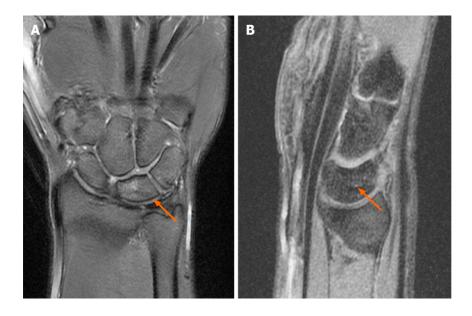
Magnetic resonance imaging follow-up 18 mo postoperatively. A: Coronal section; B: Sagittal section. These findings showed almost completely resorption of bone edema of the lunate (arrow) and did not progress into osteonecrosis.
